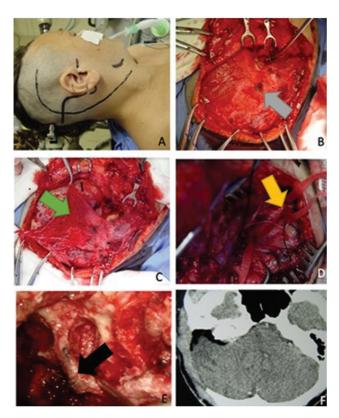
Case 2, a type C Fisch approach was chosen (A). The temporoparietal fascia and the temporal muscle are identified and individualized for pedicular flap preparation on the preoperatory period (B and C). The cervical neurovascular structures are dissected and individualized for proximal control over the carotid artery (D). After the tumoral resection, a skeletonized intrapetrous carotid artery is observed (E). A CT scan immediately postoperatory, showing a total tumor resection (F). Gray arrow: internal auditory canal. Green arrow: pedicled muscle flap. Yellow arrow: isolated carotid artery. Black arrow: portion of the skeletonized petrous carotid.
